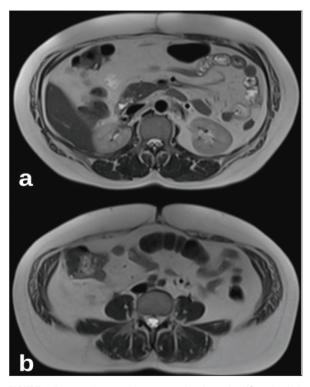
Postoperative magnetic resonance imaging at the 16th week, which shows no evidence of a residual lesion, the inflammation from the procedure had subsided, and the fat planes were clear.
